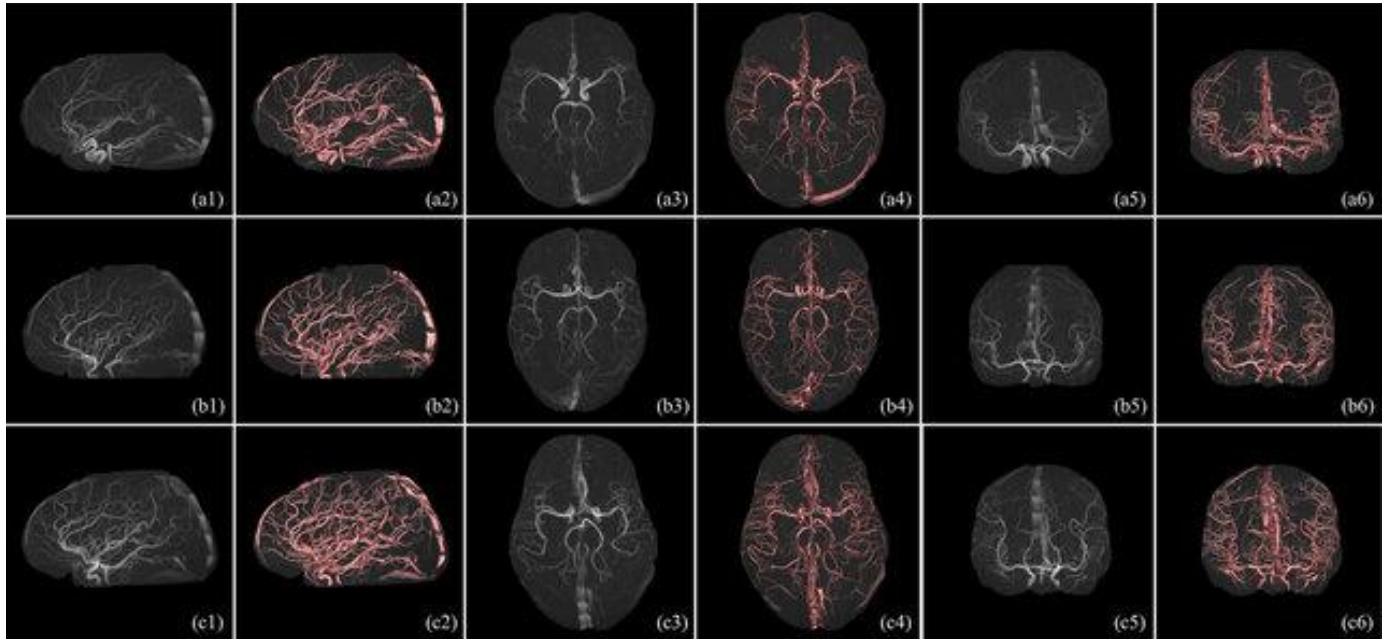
Sample multiplanar MRI and vascular overlay images from the ICBM dataset used in the study.
